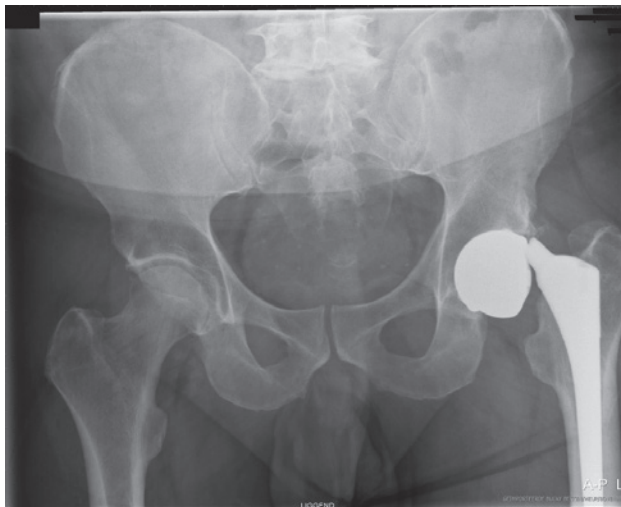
ray showing spontaneous fracture of the taper in a Metal-on-Metal big femoral head arthroplasty six years after implantation.
